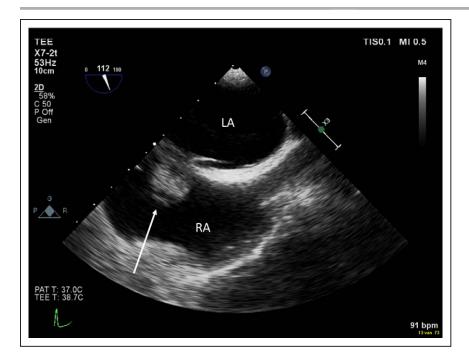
Transesophageal echocardiography (TEE)–derived image focusing on the mass in the right atrium (arrow).
